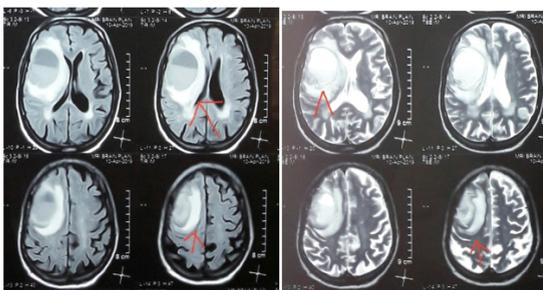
MRI BRAIN SHOWING MODERATE SIZE NECROTIC LESION IN RIGHT FRONTAL LOBE WITH MASS EFFECT.DDX: NECROTIC METASTASIS//INFECTIVE ABSCESS
